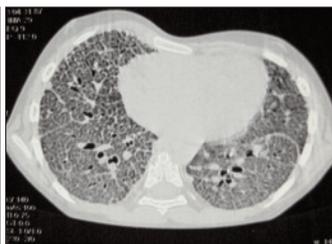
HRCT chest shows patchy alveolar opacities with interlobular septal thickening leading to crazy paving appearance.
